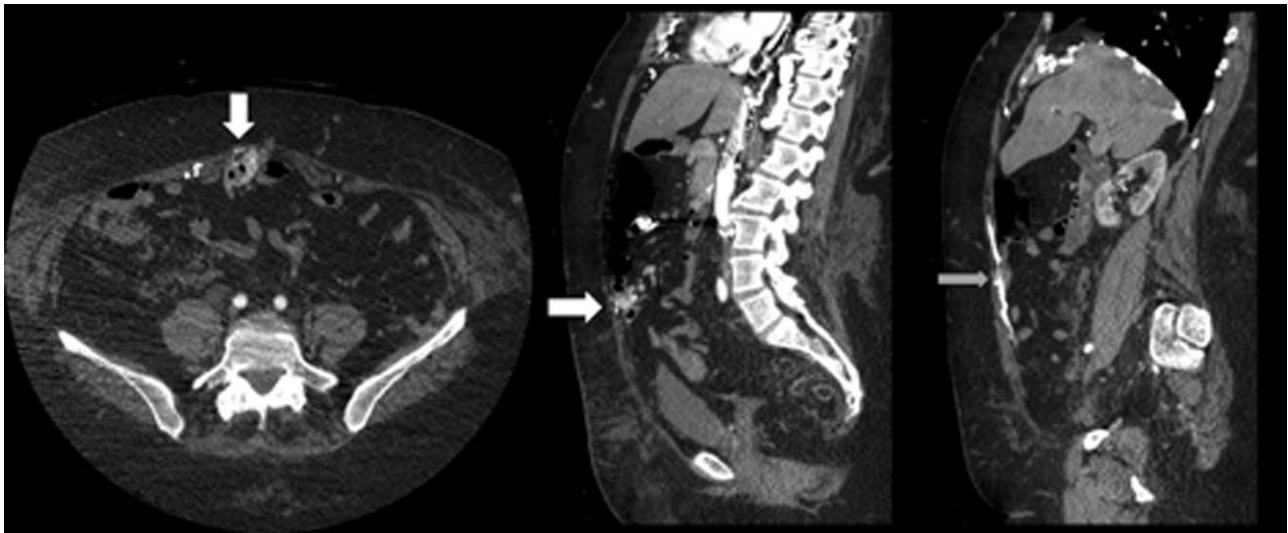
Computed tomography with intravenous contrast, venous phase. There are prominent venous collaterals (white solid arrow) encasing a loop of small bowel, showing submucosal venous enhancement in axial (left pane) and sagittal view (center pane). There are extensive collaterals along the anterior abdominal wall that drains blood from the intrathoracic veins into the inferior vena cava (right pane, grey arrow), some of which drains into the collaterals encasing the loop of small bowel.
